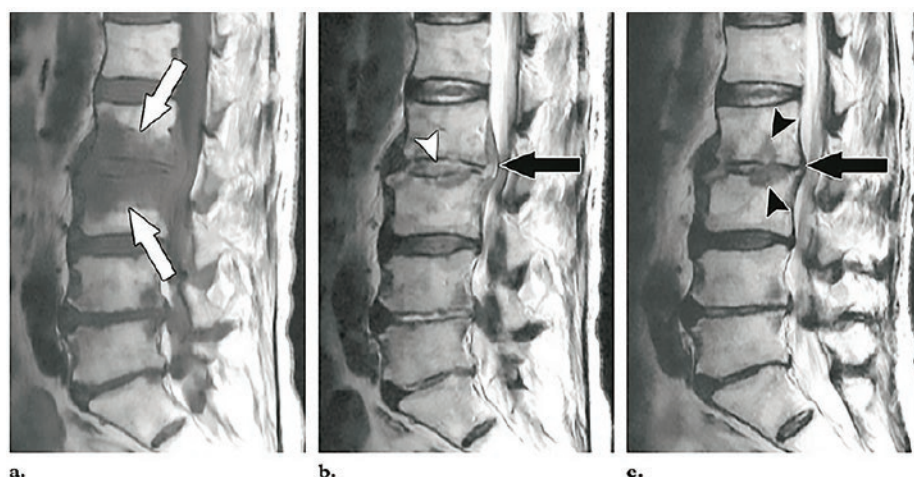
Image A displays MRI T1 WI, sagittal view; arrows indicate a hypointense signal in the vertebral bodies of L2 and L3, along with the corresponding disc. Image B displays MRI T2 WI, showing increased signal intensity in the affected disc, accompanied by an epidural abscess. Image C displays MRI T2 WI, taken two months after image B, demonstrating a reduction of the abscess, but progression of vertebral erosion.
